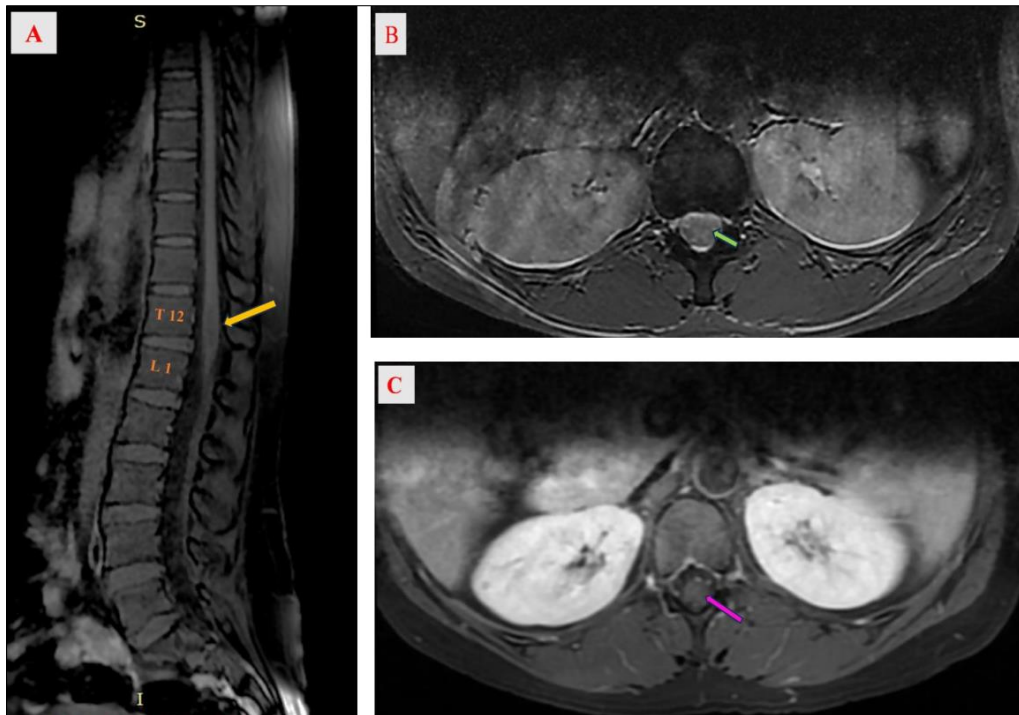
The MRI appearance of the intramedullary process. Sagittal T1 sequence (A); axial T2 (B) and T1 fat-sat sequences after gadolinium injection (C). Note the homogeneous and mildly intense enhancement (Pink arrow)
